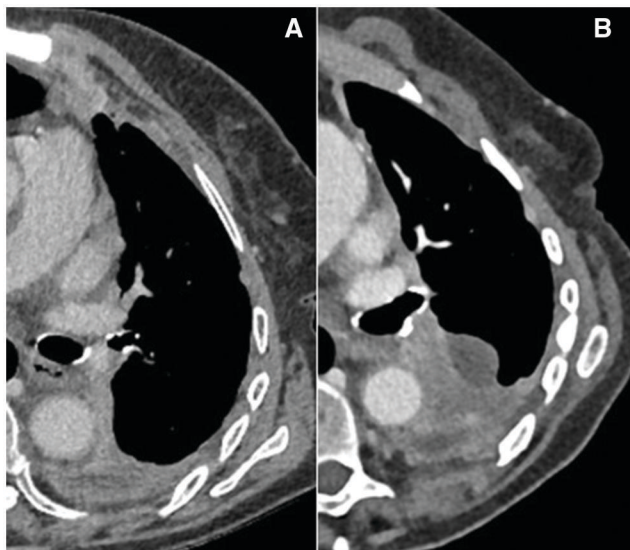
Energy integrating scintillation detectors (EIDs) CT (A) and photon-counting detector CT (PCD-CT) image (B). The left lateral pleural nodule is better appreciated on the PCD-CT image.
